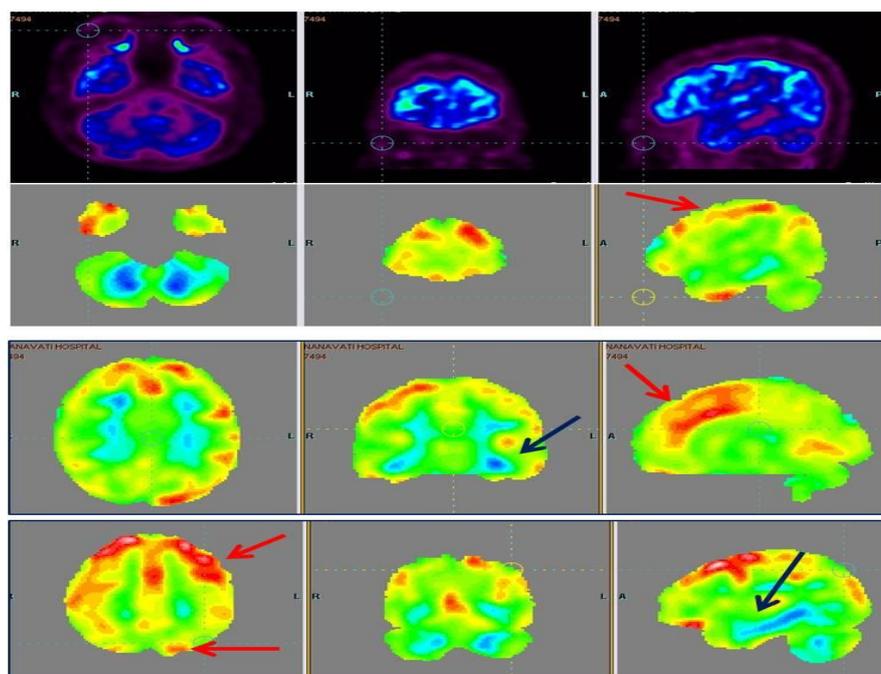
18F-FDG PET in a 16 years old boy with autism shows reduced FDG uptake (blue arrows) in mesial temporal structures like amygdala and hippocampus while increase in uptake in frontal, parietal, occipital lobes and anterior and posterior cingulate gyri.)
